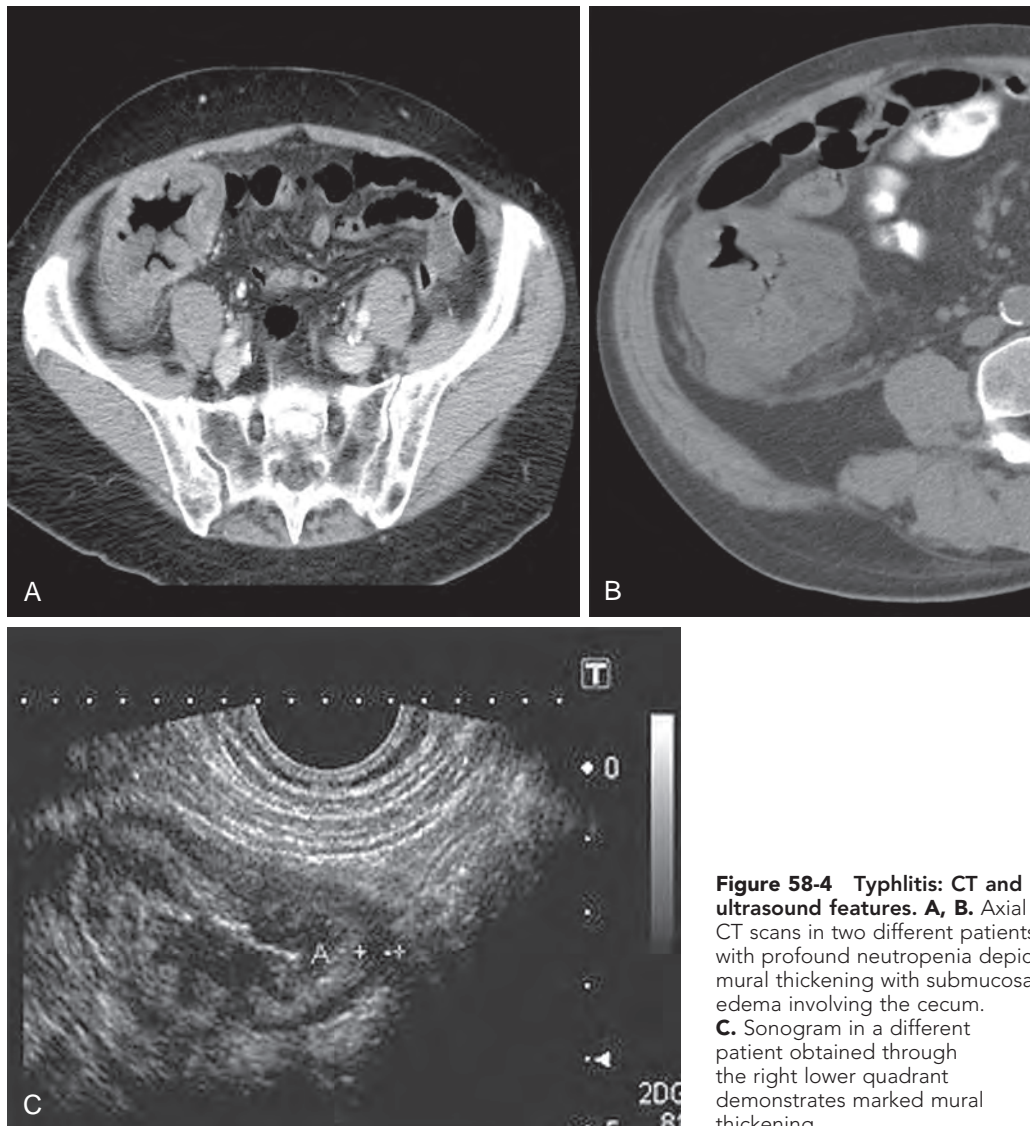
Typhlitis: CT and ultrasound features. A, B. Axial CT scans in two different patients with profound neutropenia depict mural thickening with submucosal edema involving the cecum. C. Sonogram in a different patient obtained through the right lower quadrant demonstrates marked mural thickening.
